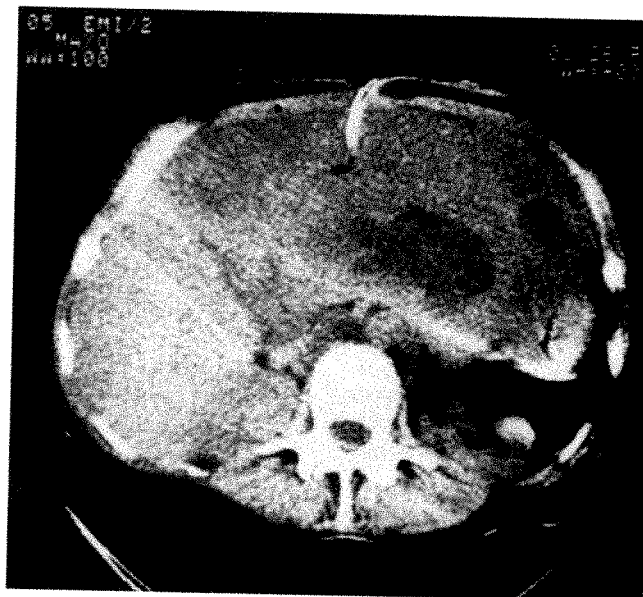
CT scan of 68-year-old woman who had previous resection of large leiomyosarcoma of pancreas containing malignant pseudocyst. Huge low density mass occupies two-thirds of abdomen. Note one large area and several small areas of even lower density within mass, indicating multiple cysts. Diagnosis was massive recurrence of leiomyosarcoma of pancreas, with multiple pseudocysts within mass. Mass extensively invaded and abutted multiple intraabdominal organs.
